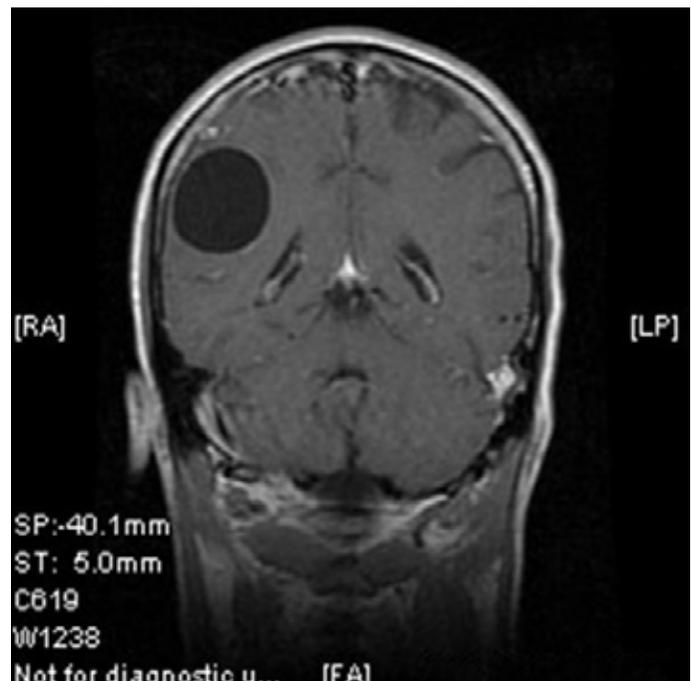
MRI revealed a cystic parietal lobe
